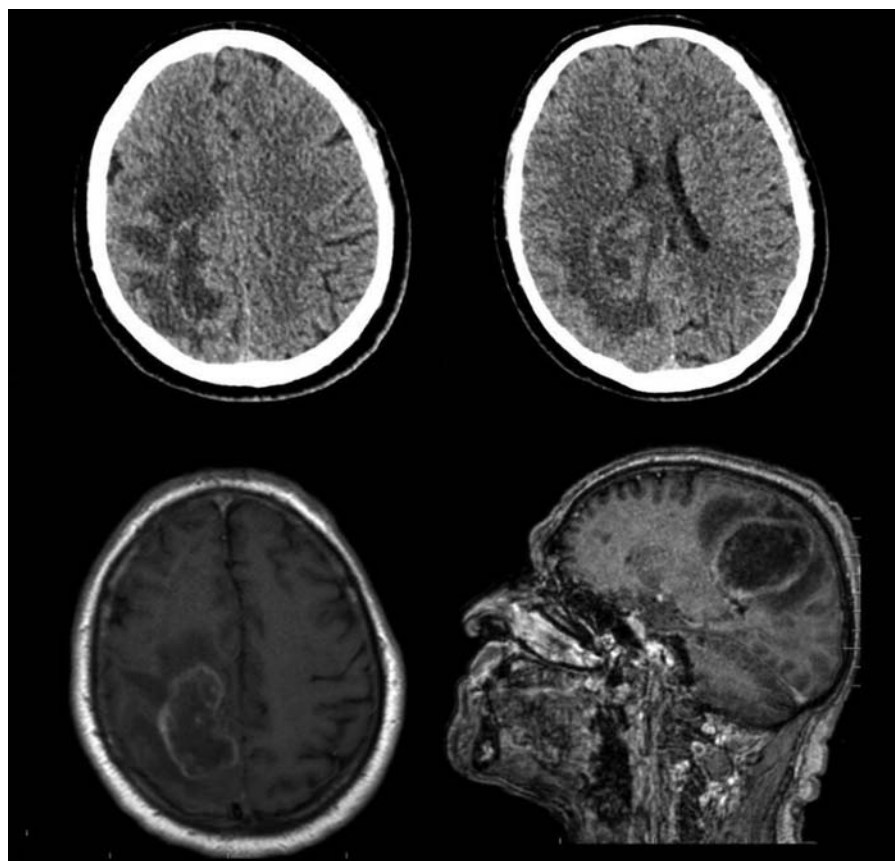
Axial cranial computed tomography scan (upper) and axial brain magnetic resonance imaging (lower) with paramagnet contrast showing a heterogeneous lesion in the right parietal convexity, with extension to the ipsilateral ventricular atrium, irregular-enhancing margins and a central necrotic core.
